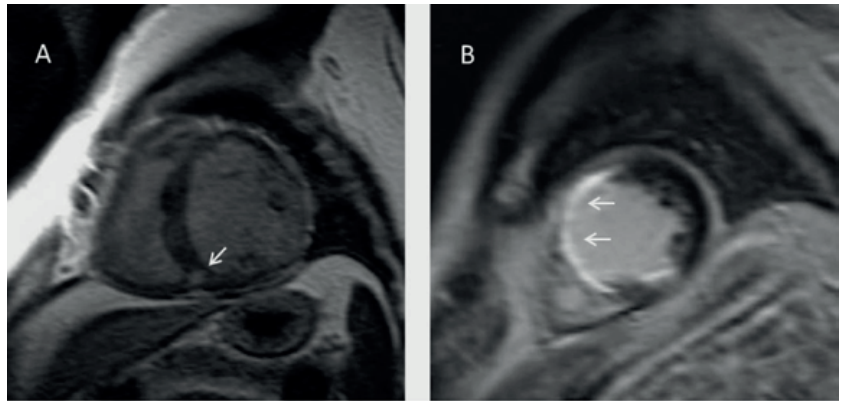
Late gadolinium contrast-enhanced magnetic resonance imaging in aortic stenosis. Panel A shows midwall focal fibrosis at the junction between the right and the left ventricle (arrow). Panel B shows infarct-like myocardial fibrosis with transmural hyperenhancement of the septum (arrows).
